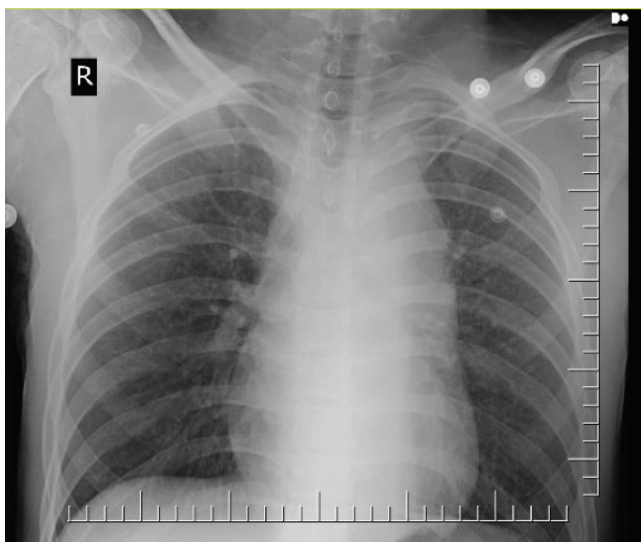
Antero-posterior Chest Radiograph; the axial sections of thoracic computerised tomography showed hematoma around the aorta and transection line.
